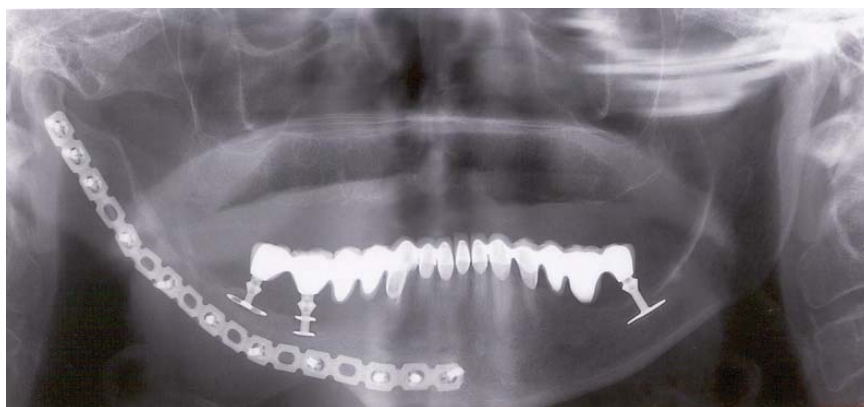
Orthopantomograph two years after implantation
